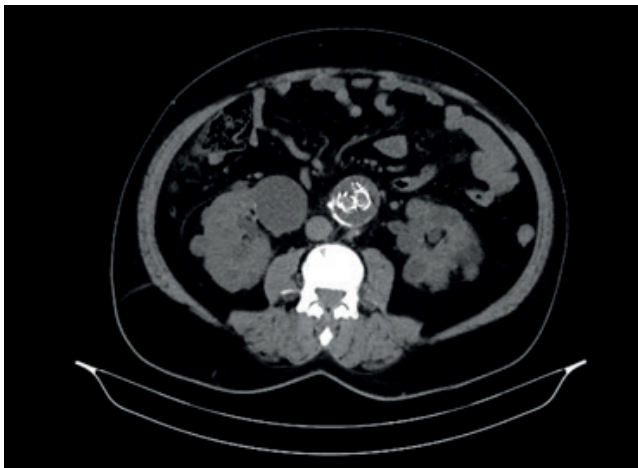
A non-contrast abdominal CT scan one year ago showed an aneurysmatic aorta, mural thrombus in the lumen, and a stent image of the EVAR procedure. No prominent infective findings were detected.
